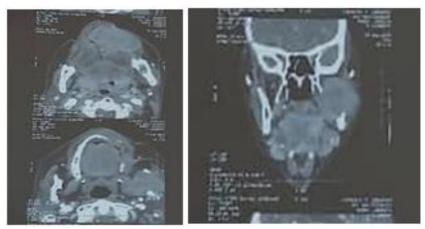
Cervico-facial CT (coronal and axial slices): left mandibular tumor process in the infratemporal fossa
